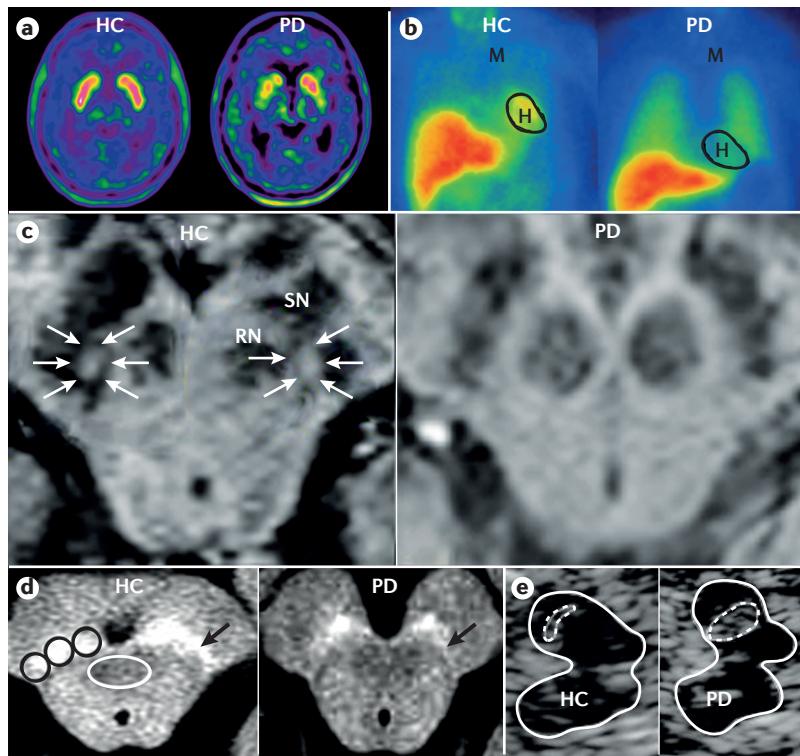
Imaging methods used to study Parkinson disease. a | ^{18}F -DOPA-PET images show normal bilateral tracer uptake in the putamen and caudate nuclei (a typical comma-shaped structure) in a healthy control (HC; left panel), whereas uptake is asymmetric with more marked reduction in the right compared with the left putamen in a patient with early-stage predominantly left-sided Parkinson disease (PD; right panel). b | Metaiodobenzylguanidine single-photon emission CT (MIBG SPECT) shows cardiac sympathetic denervation with a profound reduction in MIBG uptake in the heart (H) of a patient with early PD (right panel) compared with a HC (left panel). c | MRI of the substantia nigra (SN). Left panel shows a susceptibility weighted imaging (SWI) scan of a HC demonstrating an ovoid area of hyperintensity (arrows) within the dorsolateral SN, which is absent in patients with PD (right panel). d | Neuromelanin-sensitive MRI of the SN (black circles in the left panel) shows reduced signal intensity in the lateral part (arrow) in a patient with early PD (right panel) compared with the HC (left panel). No changes are observed in the periaqueductal grey matter (white circle in the left panel). e | Transcranial ultrasonography (axial plane) shows an enlarged area of echogenicity in the region of the SN in a patient with PD (right panel) compared with a HC (left panel). The solid lines mark the midbrain area, the dotted lines mark the echogenic area at the anatomical site of the SN on the side of insonation. M, mediastinum; RN, red nucleus. Part c is adapted with permission from REF. 237, Wiley. Part d is adapted with permission from REF. 238, Elsevier. Part e is adapted with permission from REF. 239, Wiley.
